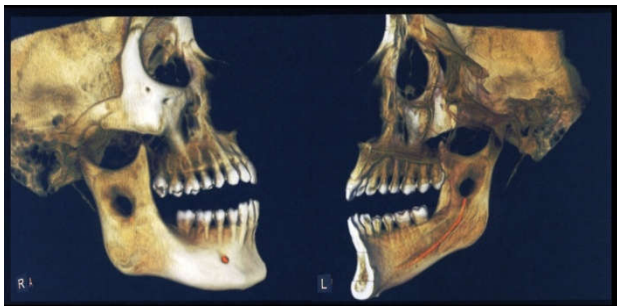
Post operative CBCT
